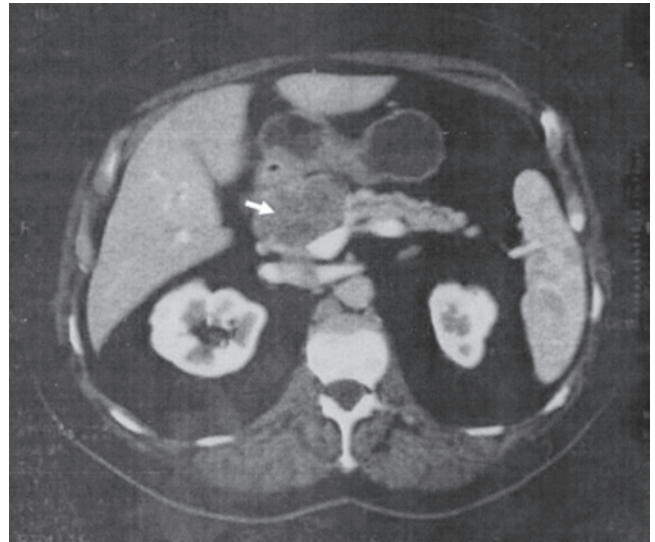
This CT image depicts a cystic neoplasm in the head and neck of the pancreas (*small arrow*) detected incidentally in a 75-year-old man undergoing evaluation for nephrolithiasis. The patient underwent a pylorus-preserving pancreaticoduodenectomy without complications. Final pathology revealed a 6-cm serous cystic neoplasm without evidence of malignancy.
